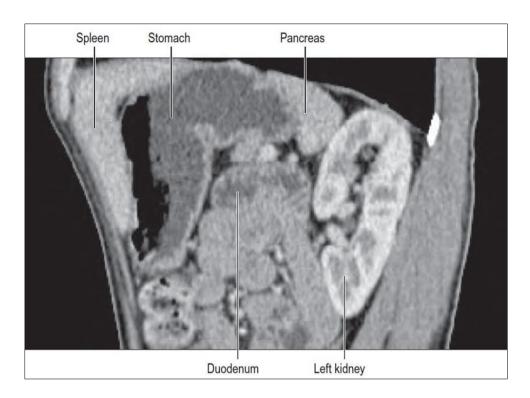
Sagittal reformat of contrast enhanced CT of the left kidney lying posterior to the stomach, spleen and pancreas.
